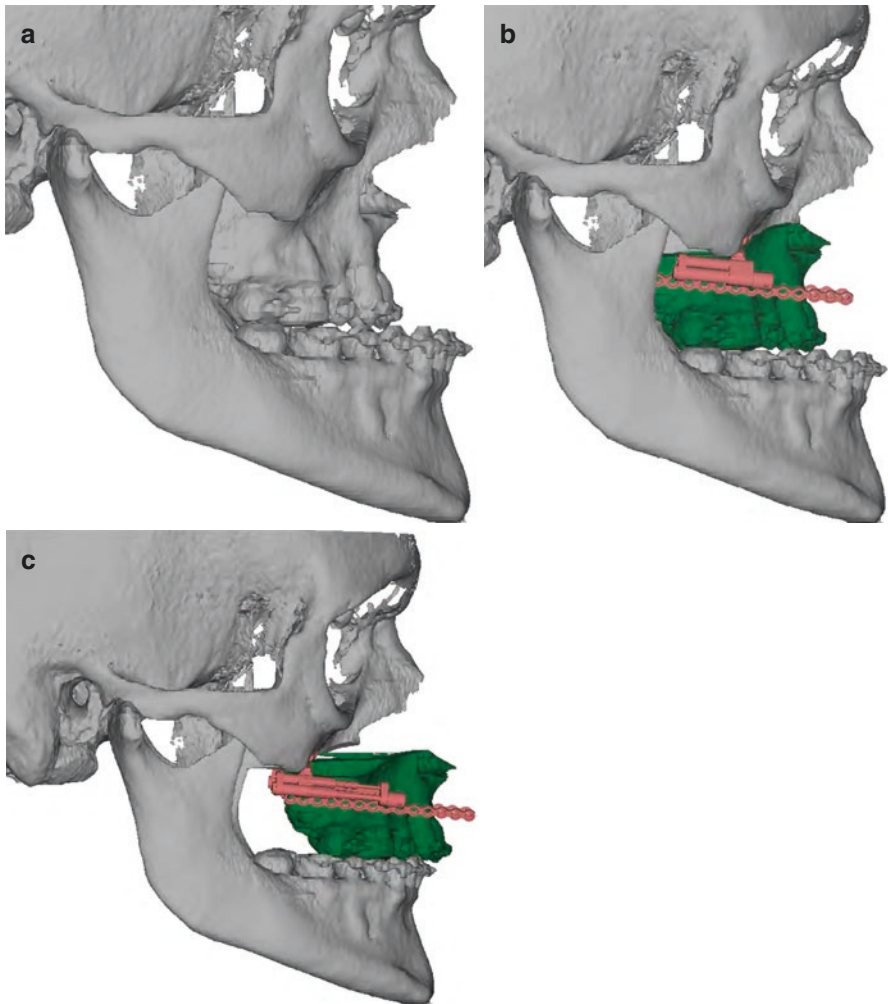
Lateral view of three-dimensional CT scan for visual treatment objective: (a) preoperative, (b) predistraction position of maxillary segment (*green*) with telescopic device (*pink*), (c) postdistraction position of maxillary segment (*green*) with telescopic device (*pink*)
